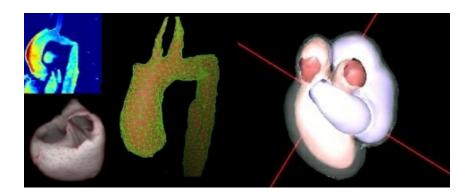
MRI image data, visualisation of segmentations of the muscle and the aorta vein trunk.
